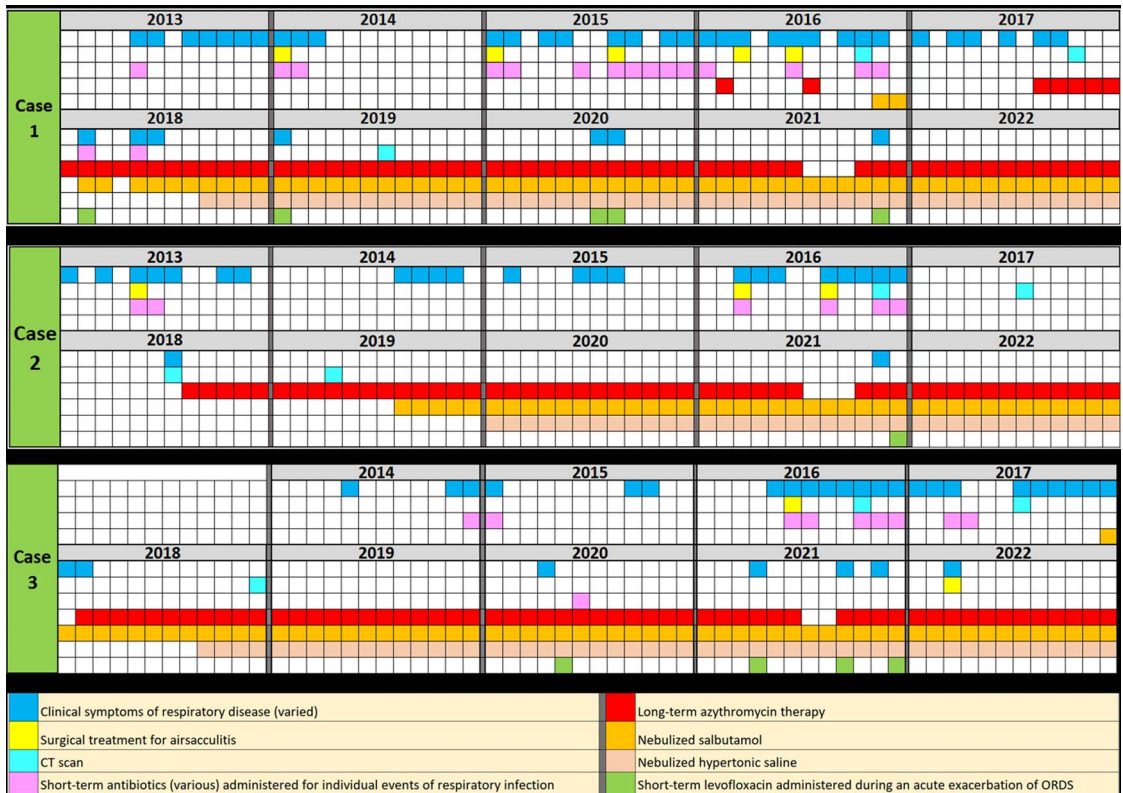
Color coded timeline of ORDS in Case 1 (top box), Case 2 (middle box), Case 3 (bottom box). Each cell represents one month. As explained in the legend at the bottom of the figure, each color represents either an observed clinical condition, treatment, surgery, or CT scan that occurred/was conducted in that month. This figure shows the period of 2013–2022, however Case 2 had the history of ORDS since 2010, which details can be referred to in the Supplemental Table 2. The chronic ORDS treatment period is marked by the long continuous rows of red (Azithromycin), orange (nebulized Salbutamol), and beige (nebulized hypertonic saline) cells. Corresponding to the long-term treatment period, it can be observed that there were much fewer blue cells that represented appearance of clinical signs.
